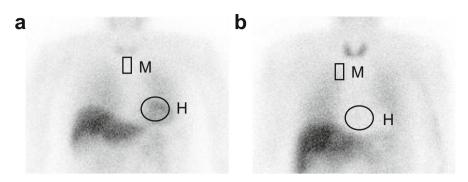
Normal (a) and reduced (b) myocardial MIBG uptake in the anterior planar image of ¹²³ I-MIBG myocardial scintigraphy. Regions of interest (ROI) are set on the heart (H) and mediastinum (M), and the H/M ratio is used to indicate the cardiac MIBG uptake
